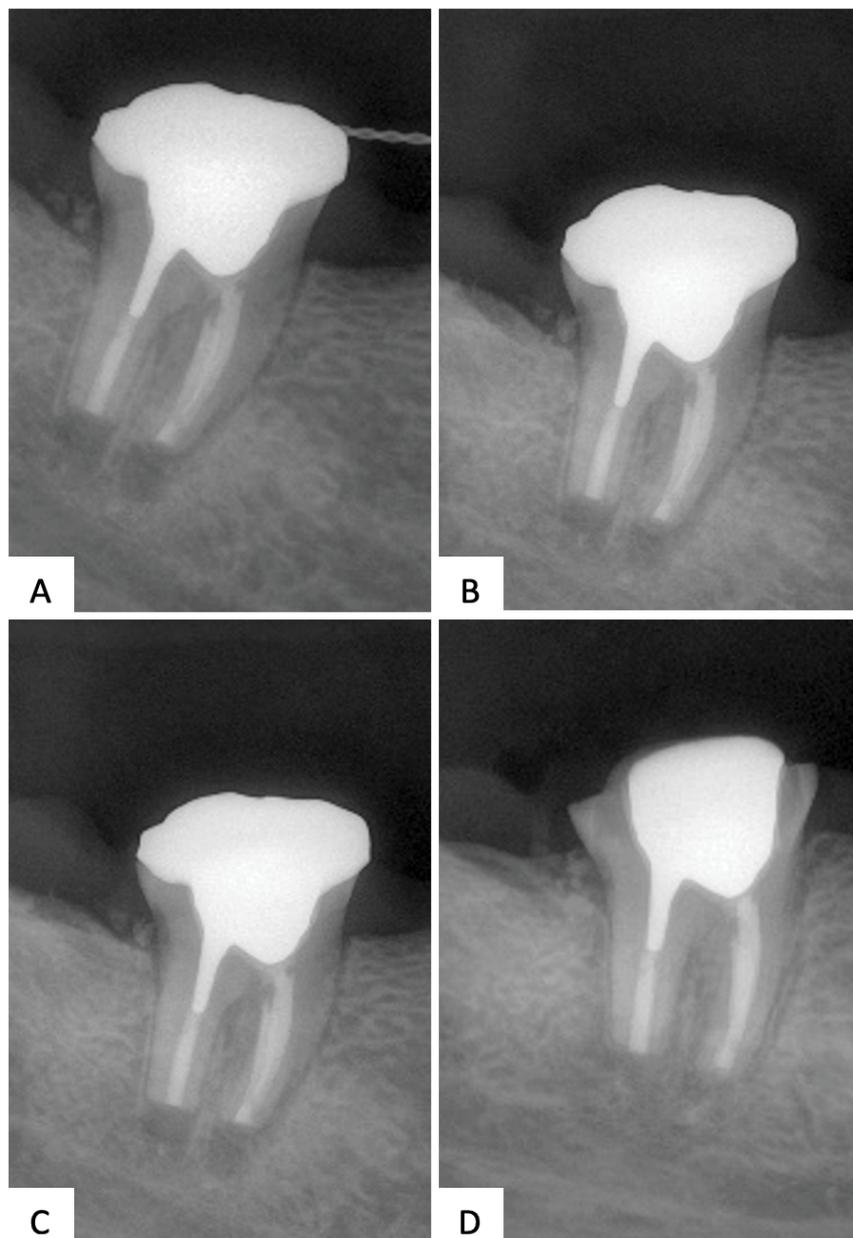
Periapical radiographs of tooth #47 in the postoperative follow-up appointments. A: postoperative periapical radiograph; B: after one-month follow-up; C: after three months follow-up; D: after one-year follow-up
